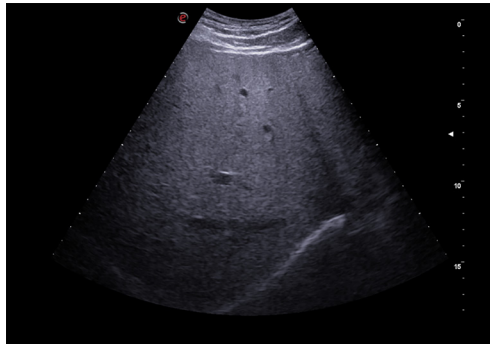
Ultrasound sonogram of fatty liver.
